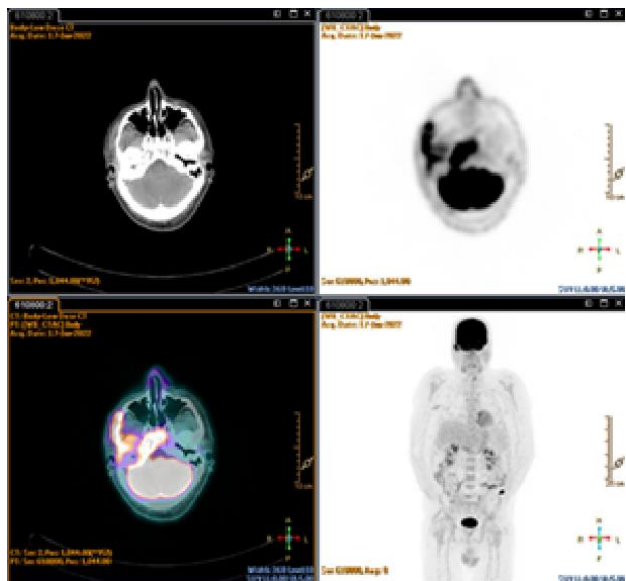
PET/CT-scan with 18F-FDG: High tracer uptake at the right foramen lacerum involving the apex of the ipsilateral petrous temporal bone, clivus and the vault of the nasopharynx, extending to the ipsilateral jugular hole. Uptake area at right temporomandibular joint with extension to ipsilateral zygomatic arch and preauricular region.
